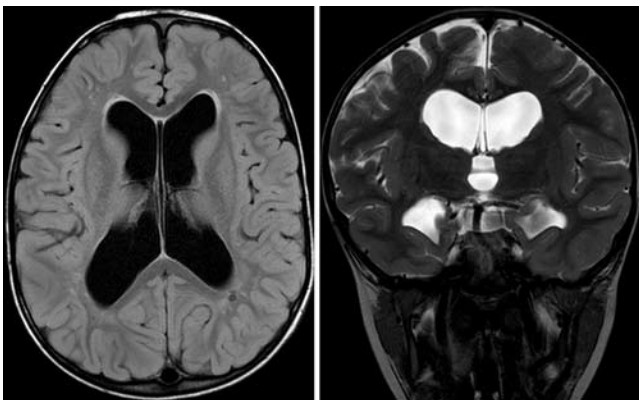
Axial FLAIR-weighted (left) and coronal T2-weighted (right) MR images obtained in a 6-year-old child with achondroplasia who had moderate ventriculomegaly and a head circumference on the 75th percentile for achondroplasia, who did not undergo shunt placement and who has had a normal developmental outcome to this point.
